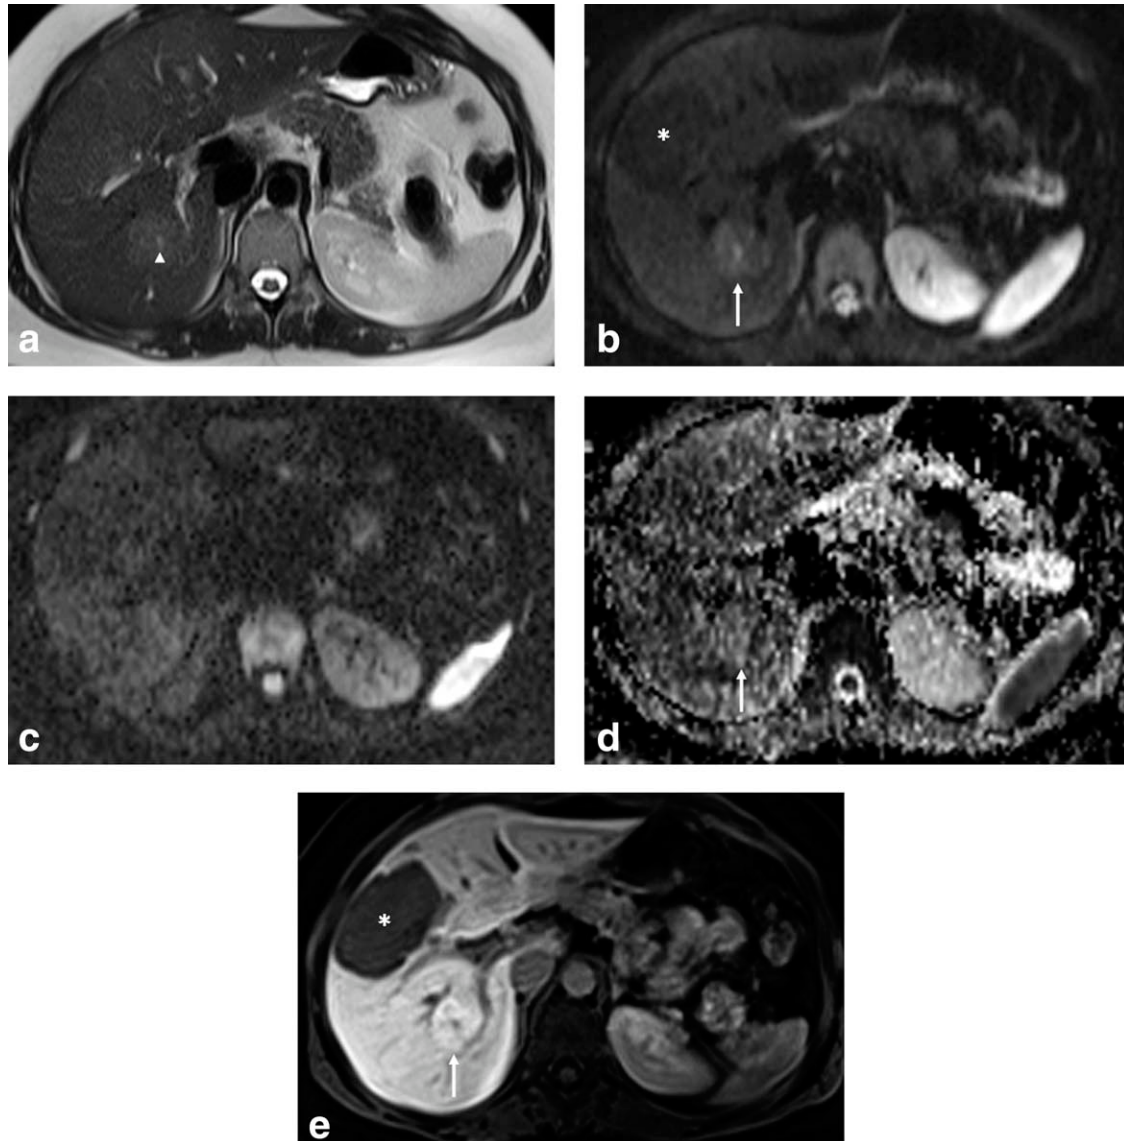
Adenoma and FNH in a 31-year-old woman. a: Transverse T2-weighted image. b,c: Transverse DWIs obtained with b-values of 50 (b) s/mm^2 and 800 (c) s/mm^2 , (d) ADC map, and (e) hepatobiliary phase MR image with Gd-EOB-DTPA. At T2WI, the adenoma is isointense and the FNH with tiny scar (arrowhead) is mildly hyperintense relative to the surrounding liver parenchyma. Both lesions were judged as indeterminate (a score of 2 was assigned) by both readers. On DWIs the adenoma (asterisk) demonstrates slightly hypointensity relative to the surrounding liver parenchyma, while FNH (arrow) displays mild hyperintensity at a b-value of 50 s/mm^2 and the signal disappears at a b-value of 800 s/mm^2 . On the ADC map, the adenoma is isointense and the FNH (arrow) is mildly hyperintense relative to the surrounding liver parenchyma. On the basis of the DWIs the adenoma was classified as indeterminate (a score of 2) and the FNH was correctly judged as benign (a score of 1) by the two readers. On hepatobiliary phase MR images with Gd-EOB-DTPA, the adenoma (asterisk) is characteristically hypointense (which may be explained by the absence of biliary tree development within this tumor) and the FNH (arrow) is mildly hyperintense relative to the surrounding liver parenchyma.
